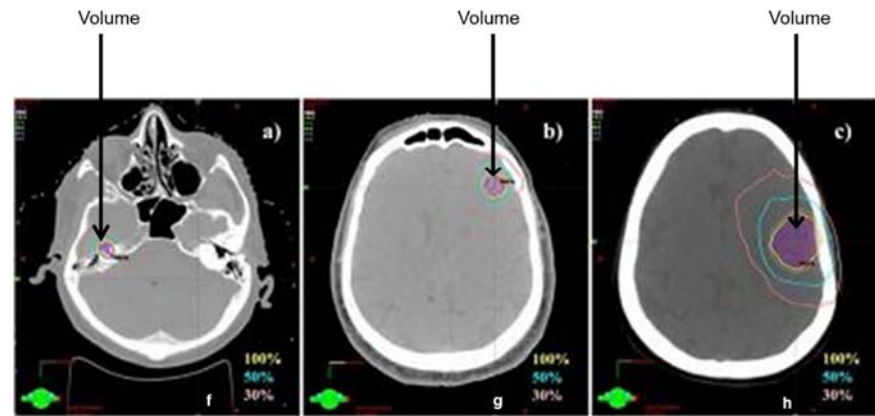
MRI impact on treatment planning:
